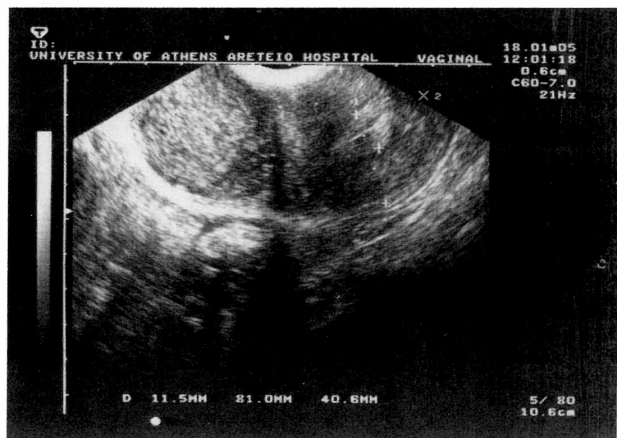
Transvaginal ultrasonogram demonstrating a solid mass of heterogeneous constitution on the posterior cervix, measuring 70 x 40 mm in dimension.
